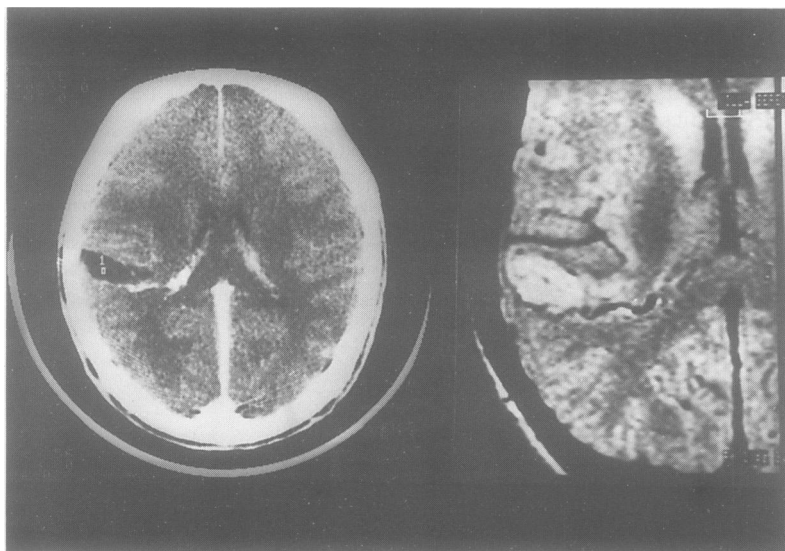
Figure Left: CT scan (2 May 1988) showing a ribbon-shaped malacic area in the right temporo-parietal region, the posterior part of which has absorbed contrast agent
